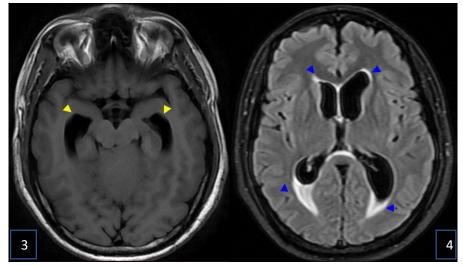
Axial non-contrast FLAIR images
